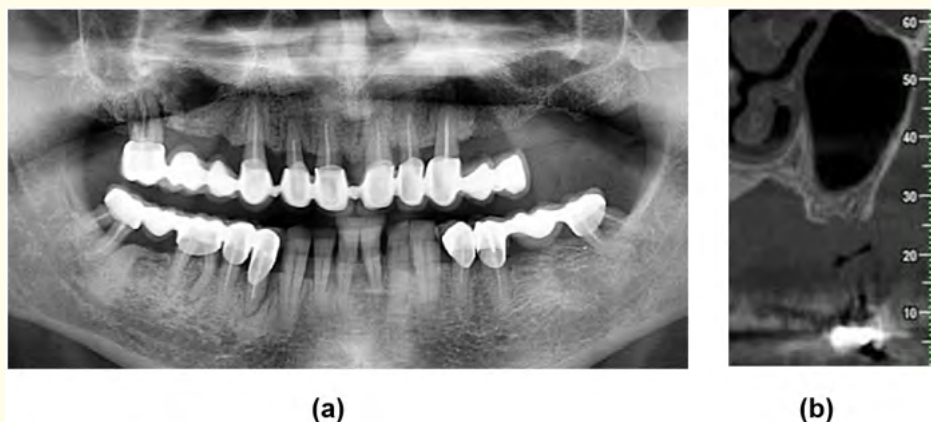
(a) Pre-operative panoramic X-ray, (b) Detail of Pre-operative CBCT showing atrophic maxilla.
